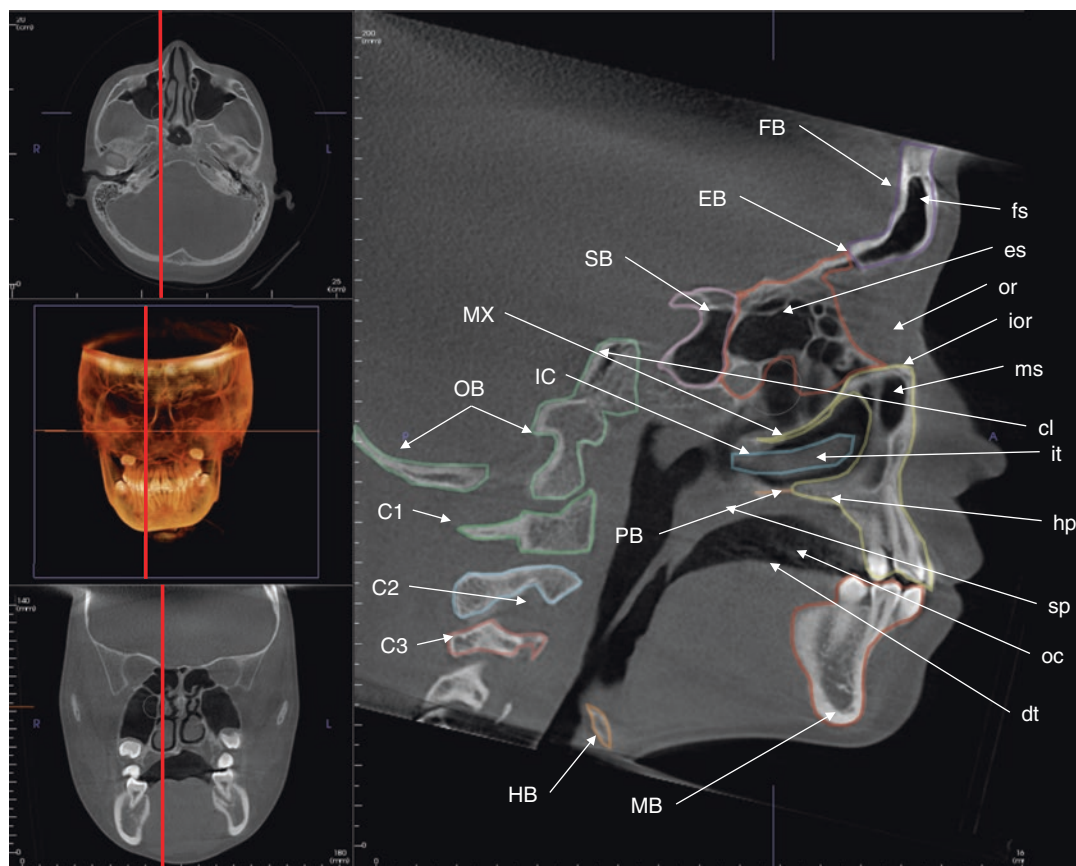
Sagittal orthogonal CBCT image at the level of the middle of the right nasal aperture (*right*) with axial (*upper left*), frontal volumetric rendering (*middle left*), and coronal (*lower left*) reference images. (FB frontal bone, LB lacrimal bone, EB ethmoid bone, SB sphenoid bone, IC inferior conchae, PB palatal bone, OB occipital bone, MX maxilla, C1 Atlas/first cervical vertebrae, C2
